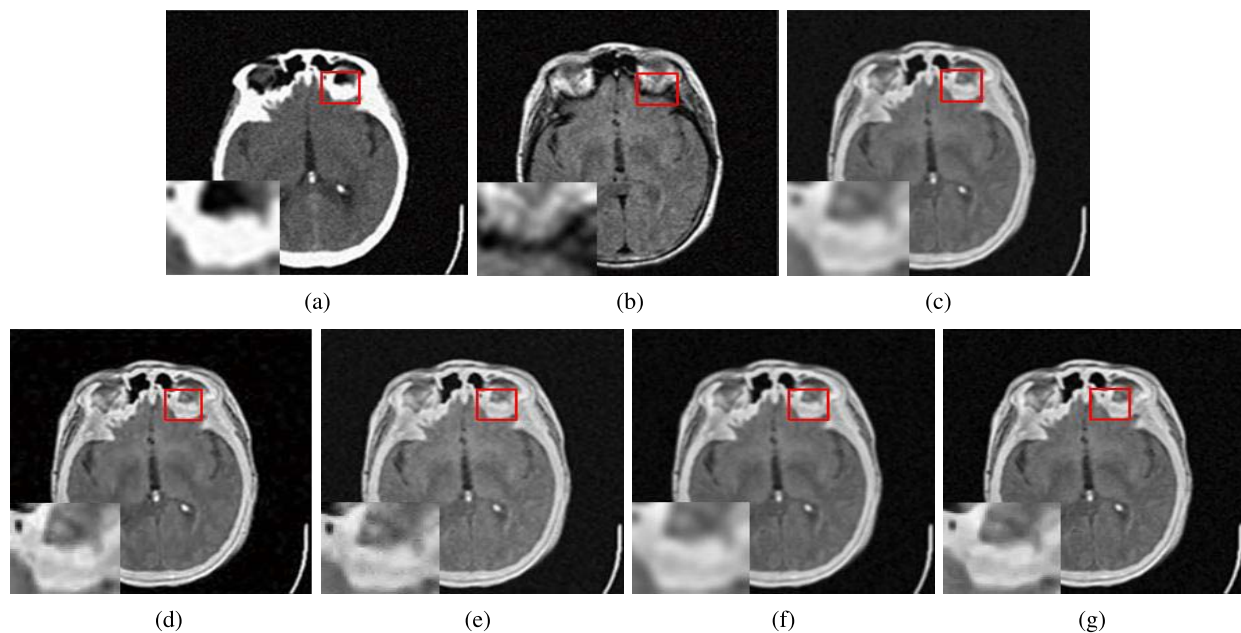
Input images that are added an 11.51-dB SNR and fusion result comparison with different methods. (a) Noisy CT image. (b) Noisy PD image. (c) SR. (d) NGWT. (e) TVPL. (f) BM3D + GFF. (g) Proposed method.
